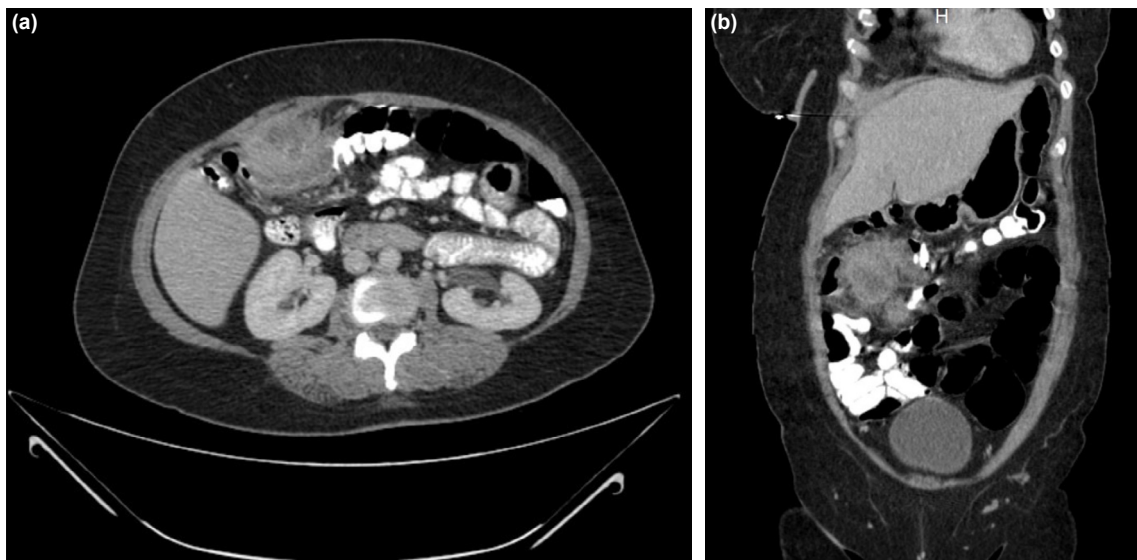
(a, b) CT scan showing wall thickness of the proximal transverse colon.
